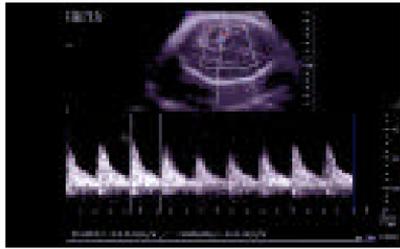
Ultrasound image of cross-section through fetal brain, with color Doppler visualization of circle of Willis and measurement of peak flow velocity in fetal middle cerebral artery (MCA).
